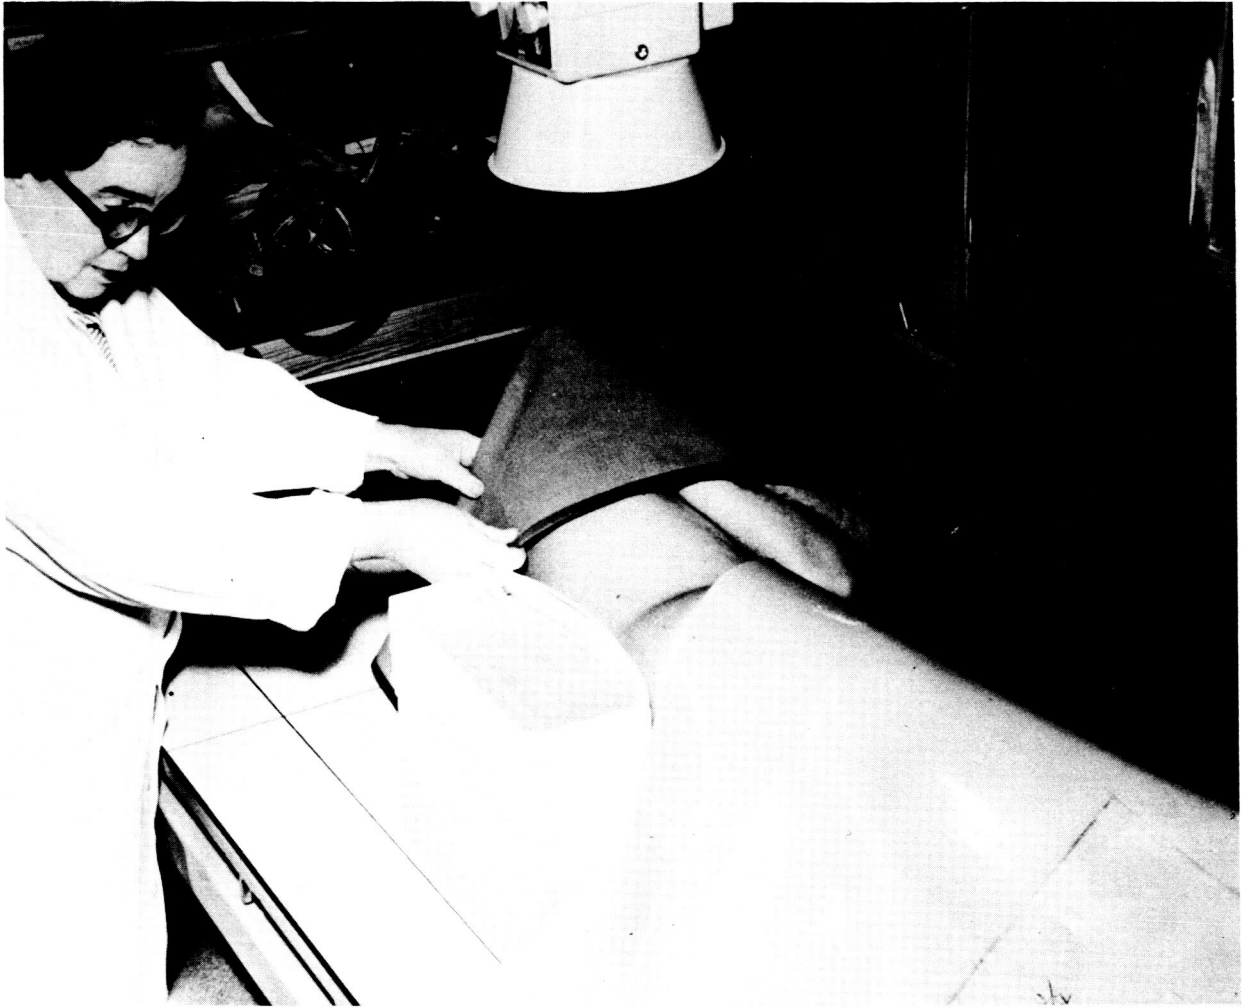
Position of subject for making lateral roentgenogram of the lumbar spine. The wedge is embedded in plates of plastic which have an X-ray transmission similar to that of soft tissue surrounding the spine. The wedge is located at the level of the spine. The subject is being covered with lead sheeting except for the area of the third and fourth lumbar vertebrae.
